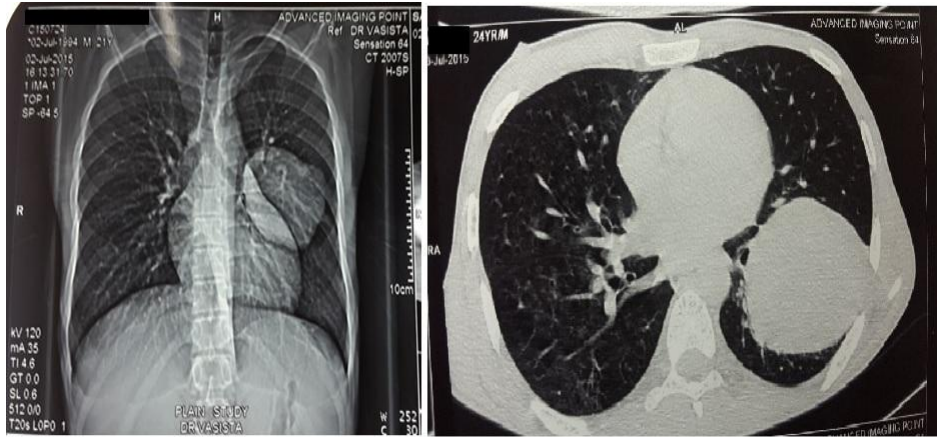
CT scan showing mass in the left lung
